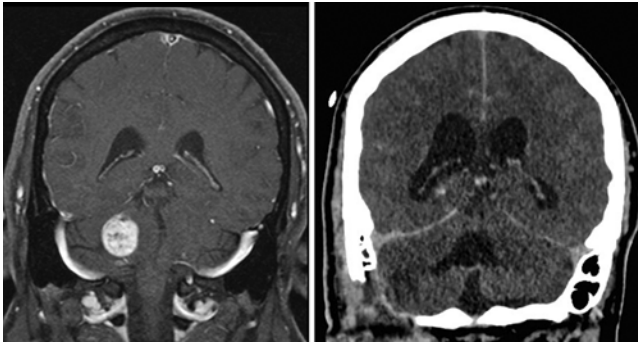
Hydrocephalus. Left: Preoperative coronal postcontrast T1-weighted MRI study showing a right cerebellopontine angle schwannoma. Right: Postoperative coronal CT scan showing interval enlargement of the ventricular system following right retrosigmoid resection, requiring ventriculoperitoneal shunt insertion. The patient had postoperative meningitis.
